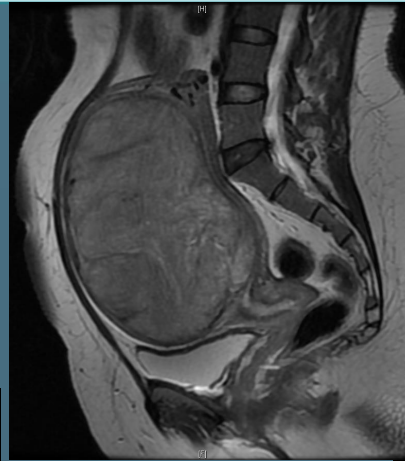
MRI Pelvis pre-UAE. Fibroid measures 15x9x9cm
